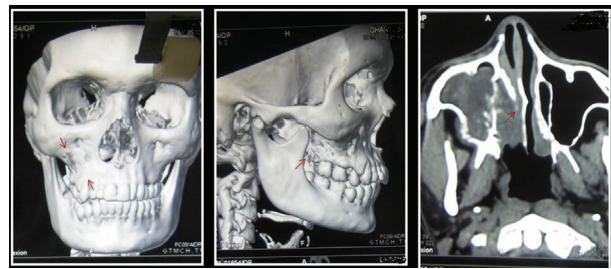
3D reconstructed CT images reveal loss of the normal trabecular pattern in the alveolar bone from the facial aspect of the right maxillary first premolar to the right maxillary third molar, suggesting involvement of a pathological lesion in this region (left). A focally destructive mass is observed extending from the infrazygomatic surface toward the posterior surface of the maxilla (middle). A diffuse lesion is also noted within the left maxillary sinus with deviation of the nasal septum (right).
